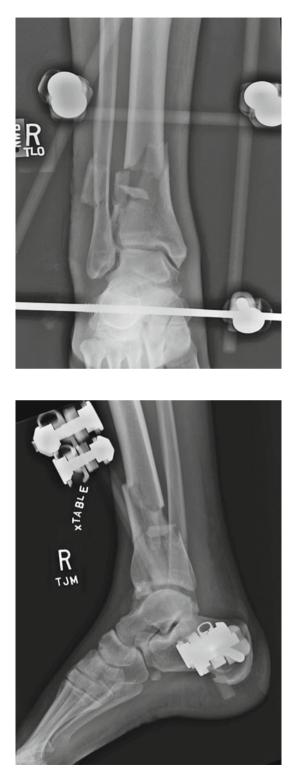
Lateral radiograph following the closed reduction and application of external fixation
